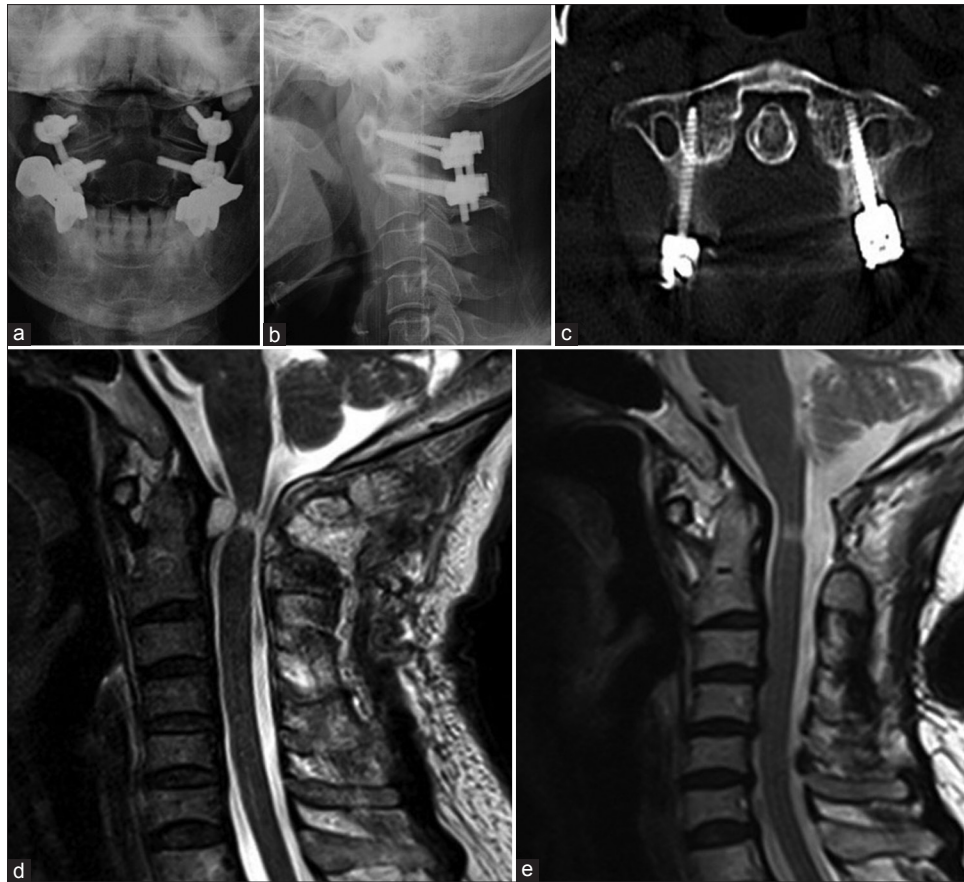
(a and b) Postoperative open mouth anteroposterior radiograph and lateral radiograph showing the rigid fixation between C1-C2 and atlantoaxial joint had been reset. (c) Postoperative computed tomography showed that atlantoaxial joint had been reset. (d) Postoperative sagittal T2-weighted magnetic resonance image showed that the mass still compressed the spinal cord. (e) Sagittal T2-weighted magnetic resonance image taken 24 months after surgery showed that the mass was no longer present
